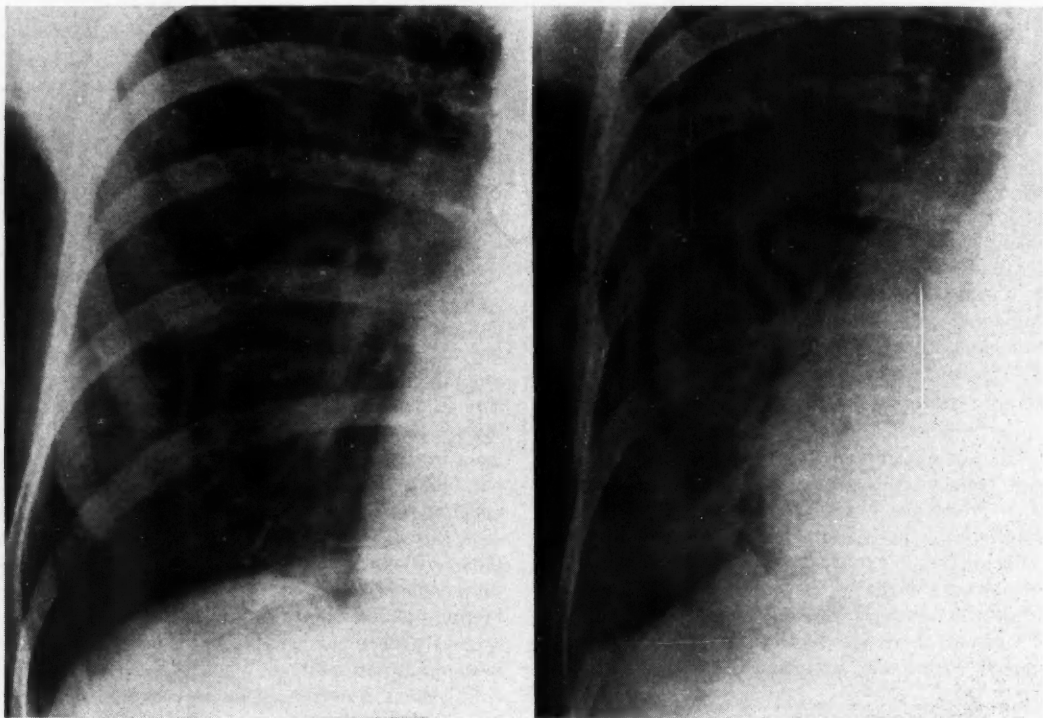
X-ray films in a case of long-standing mitral stenosis. No septal lines present in the film at left. In the picture at right, three years later, after development of mild pulmonary hypertension and recurrent congestive failure, numerous septal lines are visible.
